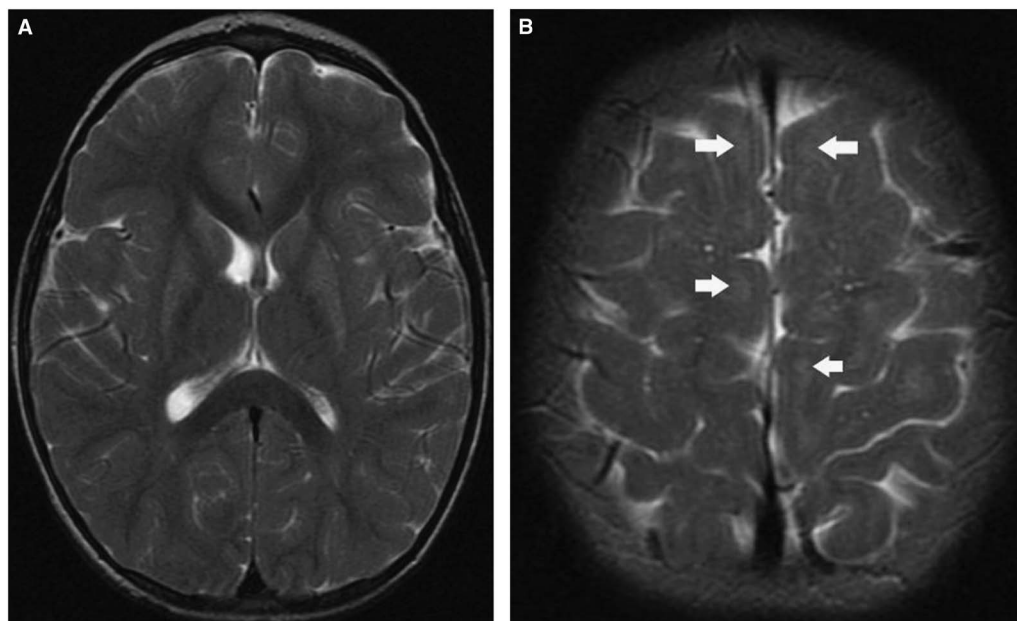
Brain MRI of a boy with mitochondrial disorder caused by complex 1 deficiency performed when he was 4 years and 8 months old. Axial T2-weighted images (TR 2417, TE 123.3) showing hyperintense signal abnormalities in the basal ganglia, especially in the head of the caudate nuclei and putamina (A), and subcortical cerebral white matter bilaterally (arrows) (B).
